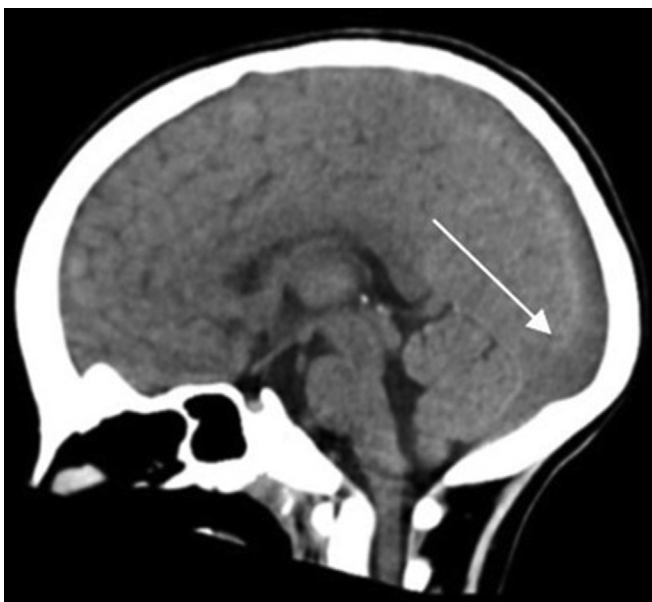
CT image of a 4-year-old male patient, with sagittal reconstruction showing marked hypodensity of the superior sagittal dural sinus (arrow), which becomes particularly evident when comparing with the normal cerebral parenchyma.
